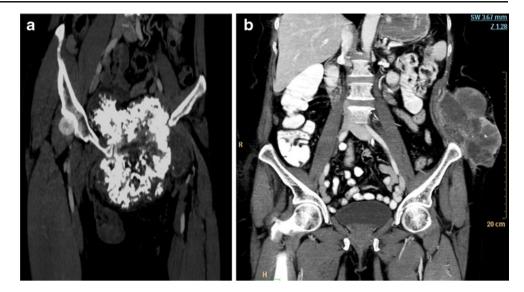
a Plain CT image showing pelvic chondrosarcoma with expensive calcification b CT scan image of abdominal wall STS. Underlying iliac bone is not involved
